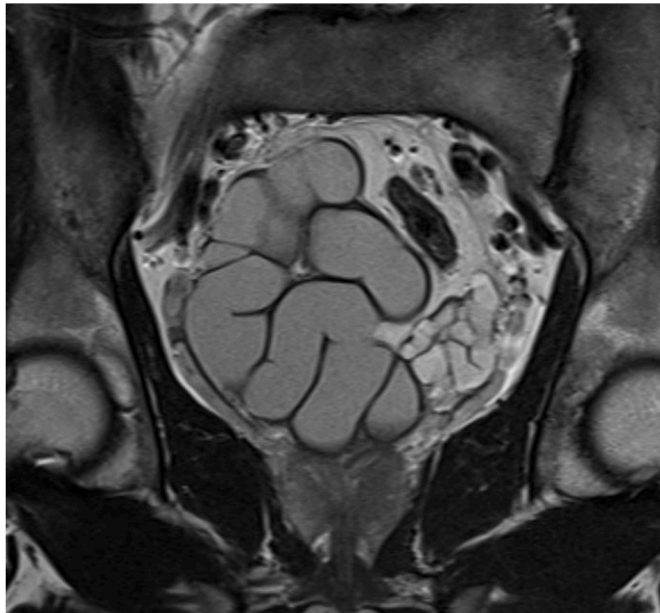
MRI, coronal section showing dilated right seminal vesical with mild dilated left seminal vesicle due to contralateral compression.
